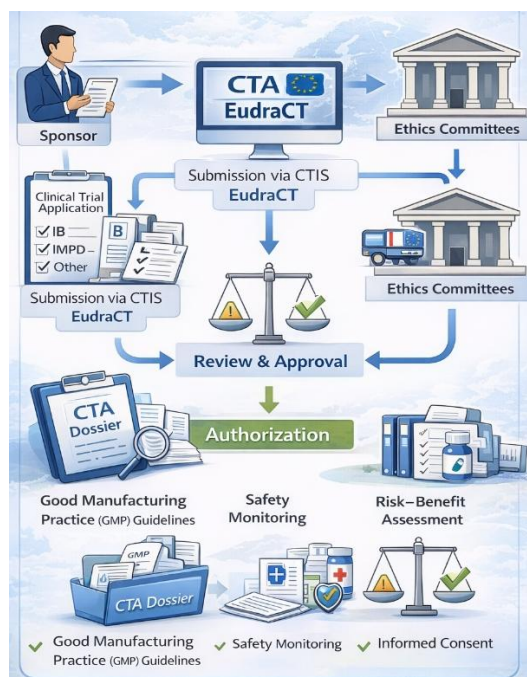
Regulatory submission pathway of the Ebselen Phase II clinical trial in the European Union. The CTA dossier is submitted via CTIS/EudraCT and evaluated by AIFA and the Ethics Committee, with assessment of GMP, safety monitoring, and risk-benefit balance prior to trial authorization.
